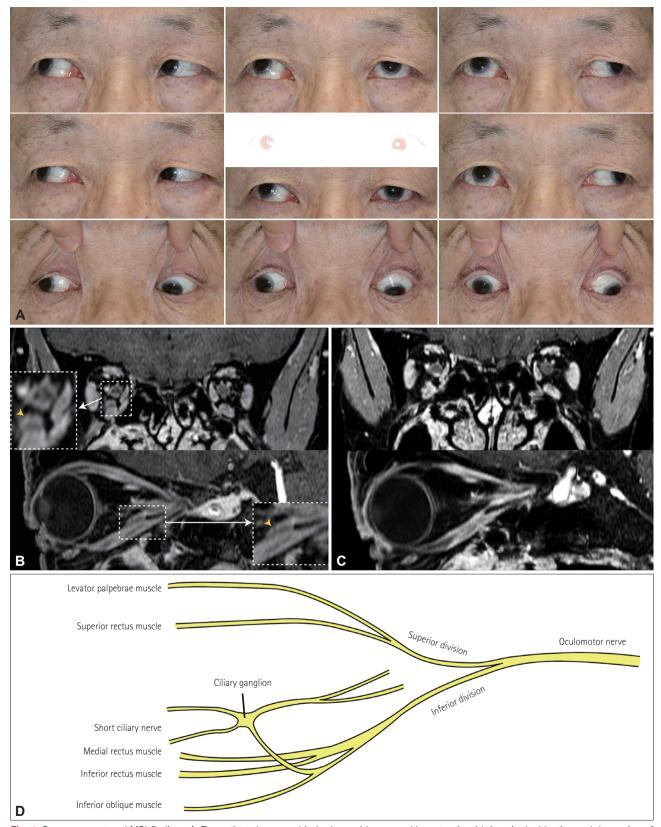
Eye-movement and MRI findings. A: The patient shows mydriasis along with exo- and hypertropia with impaired adduction and depression of the right eye. B: Contrast-enhanced T1-weighted MRIs using a 3D turbo field echo sequence with a thickness of 1 mm show a gadolinium-enhanced swelling in the inferior division of the right oculomotor nerve (arrowheads) in the orbit. C: Resolution of the lesion 1 month after chemotherapy. D: Anatomy of the oculomotor nerve.
